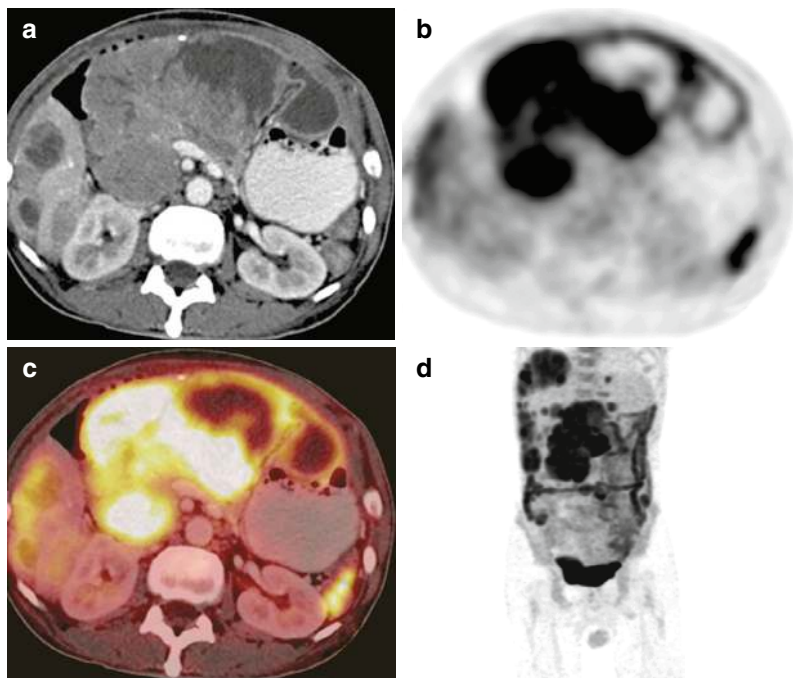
Primary pancreatic lesion showing local infiltration on CT image a and corresponding to images b, c, and d showing diffuse increased uptake secondary to the infiltration to adjacent stomach
